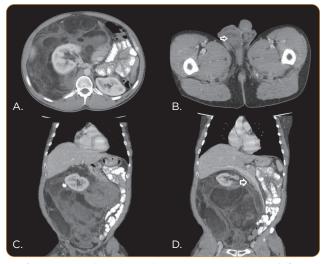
CT images prior to surgery. (A) Axial view of tumor surrounding the right kidney with displacement of intra-abdominal organs. (B) Axial view at level of the scrotum. Arrow identifies thickened fat that surrounds the spermatic cord. (C) Coronal view of tumor surrounding the right kidney with significant displacement of the intra-abdominal organs. (D) Coronal view of tumor. Arrow identifies displaced portal vein.
